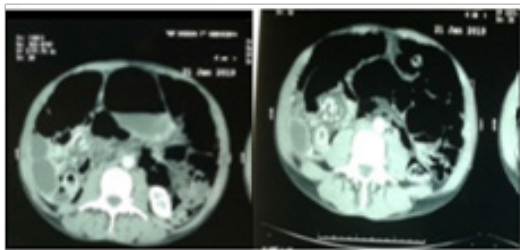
CT images of our patient showing small bowel volvulus with intestinal distention and upstream.
